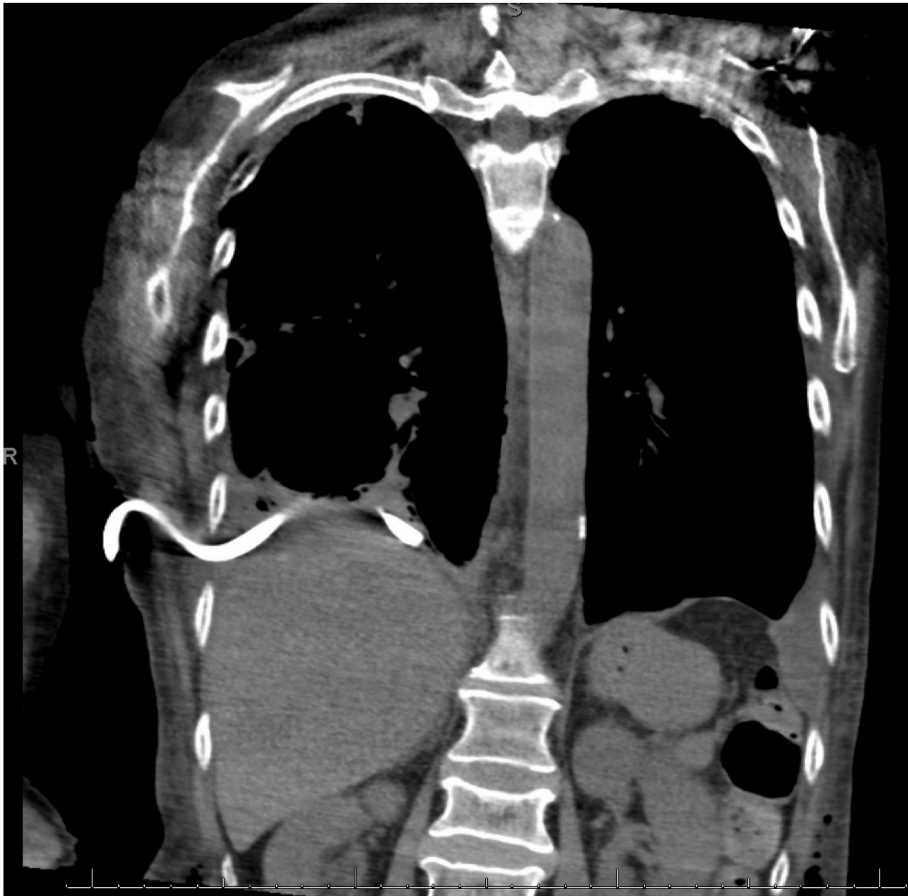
Day 12 CT Chest with IV Contrast.
